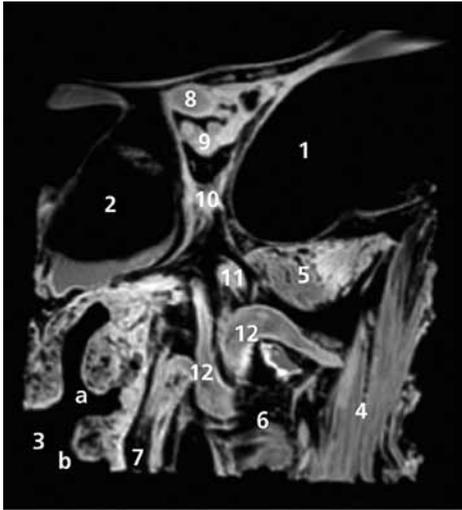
Coronal MR image of left PPF
